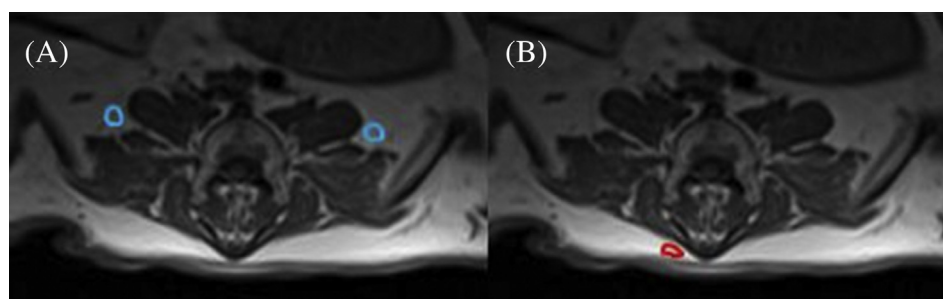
Region of interest of (A) intermuscular fat and (B) subcutaneous fat in an axial T1-weighted image at L6.
